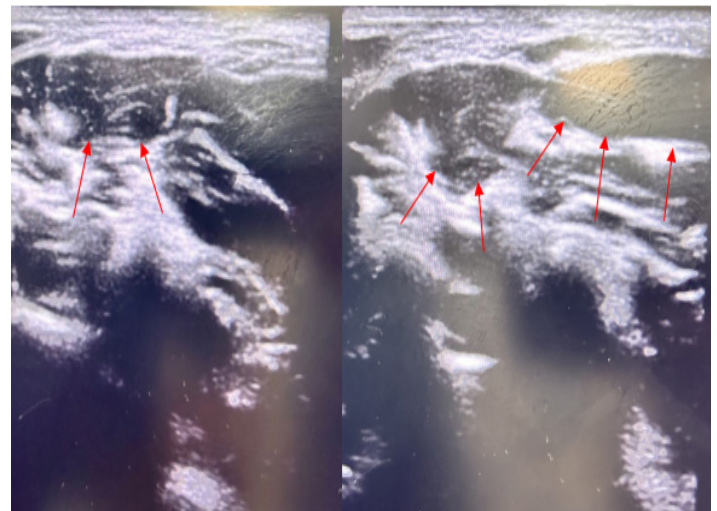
1: Ultrasound of neck showing enlarged cervical lymph nodes (Left side). Lymph nodes in usg are hypo echoic in normal.
